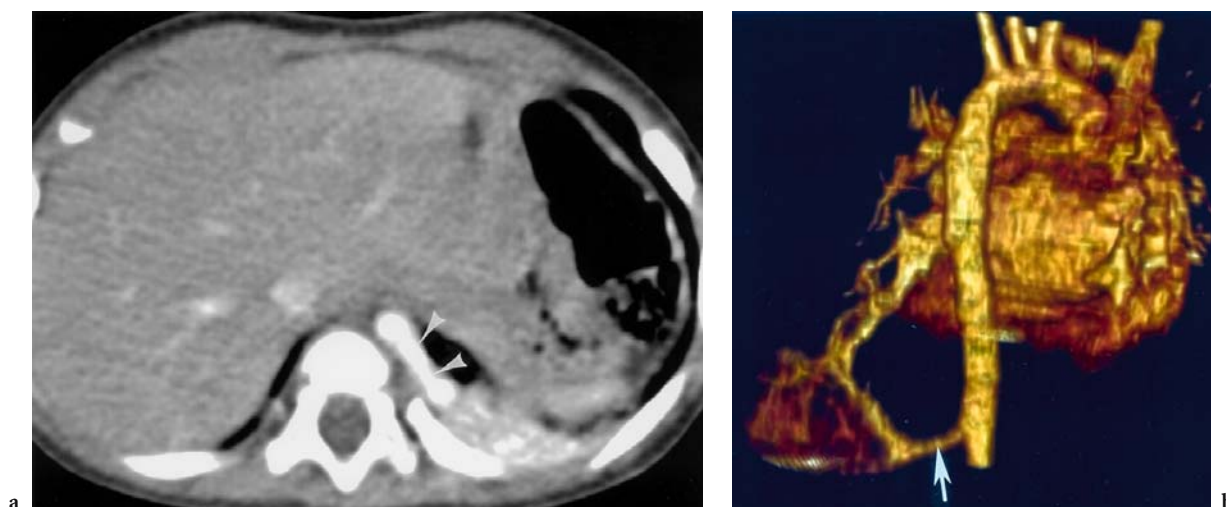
Intralobar pulmonary sequestration. A: Axial contrast-enhanced CT section demonstrates a vessel (arrowheads) arising laterally from the descending thoracic aorta and extending to an area of left lower lobe opacity. B: Three-dimensional volume rendering shows the feeding artery (arrow) arising from the aorta and extending to the lower lobe sequestration. Drainage was via a pulmonary artery, which entered the left atrium
